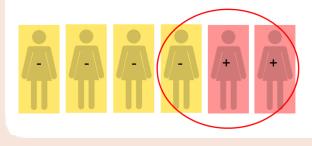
CT Screening Coverage Can Affect Positivity Estimates
